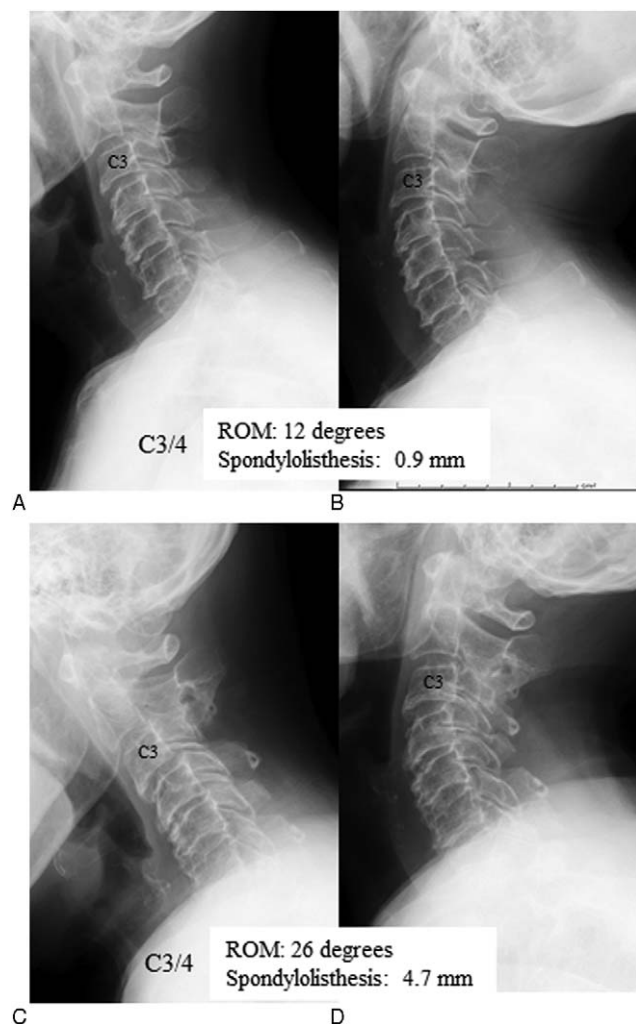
Radiographic images of a 77-year-old woman, before (A, B) and after (C, D) cervical laminoplasty. The segmental range of motion (ROM) at C3–4 increased from 12° to 26°. Spondylolisthesis at C3–4 increased from 0.9 to 4.7 mm. (A, C) Flexion; (B, D) Extension.
